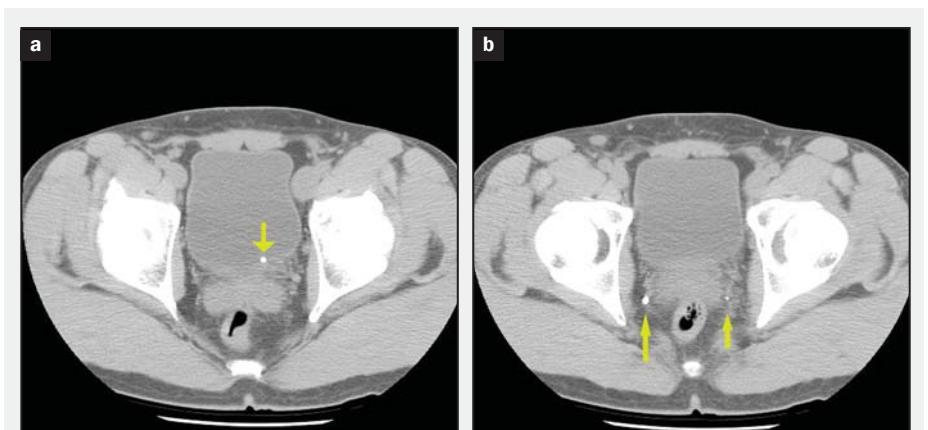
CT scan through pelvis.
